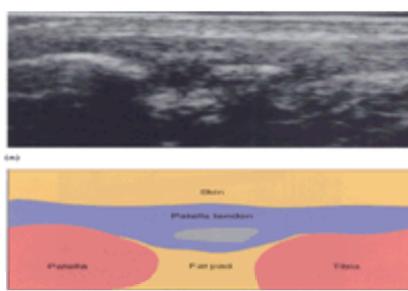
Calcific tendinitis in a 27-year-old chauffeur with pain in his knee. Ultrasound of the patellar tendon shows a thickened proximal part with a hypoechoic area inferiorly. A large focus of calcium is seen. (By courtesy of Dr S. Burnett, St Mary's Hospital.)
